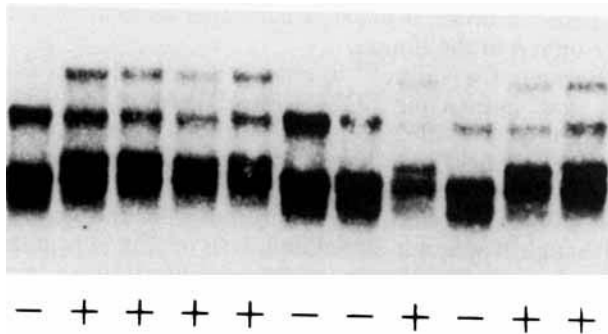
SSCP analysis of exon 2 in the CCK-B receptor gene in members of the family carrying the mutation. Primers used were Ex2-F and Ex2-R. PCR was performed incorporating ^{35}S -ATP, and the samples were electrophoresed in 6% acrylamide gel with glycerol at room temperature and exposed to X-ray film. +, lane with mutated bands; -, lane with wild-type alleles.
